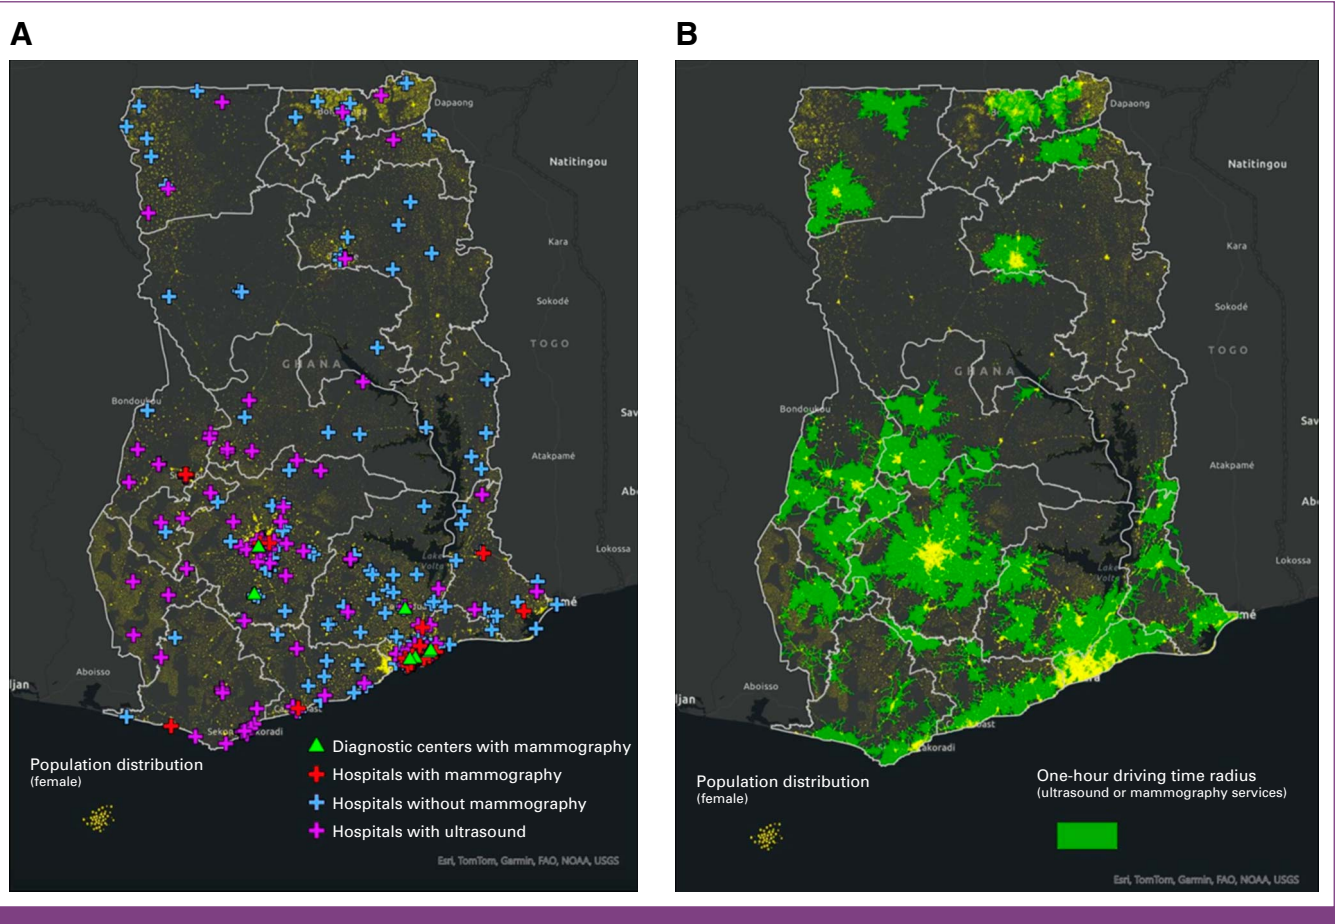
Nationwide breast imaging coverage (mammography or ultrasound) in Ghana. (A) Geographic location of hospitals and diagnostic centers with mammography or breast ultrasound services and hospitals without mammography services. (B) Assessment of 1-hour drive time to mammography or breast ultrasound services.
